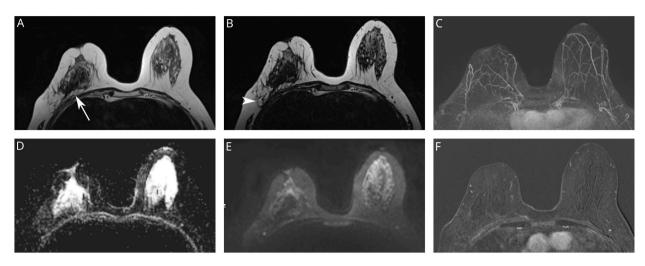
(A) T2-weighted sequences show asymmetric density and infiltration of the prepectoral fat pad (arrow). (B) T2-weighted sequences show marked architectural distortion due to a poorly defined hypo-intense mass (arrowhead) in the outer quadrant, which also causes nipple retraction. (C) On maximum intensity projection, asymmetry of breast size with a shrunken right breast is the main MRI sign of lobular carcinoma. No pathologic post-contrast enhancement is noted. (D) Diffusion-weighted image of *b-800* and (E) Apparent diffusion coefficient show that the mass is large and extends from the retro-areolar region to the pre-pectoral region, with infiltration along the areolar region and nipple. (F) Axial subtracted T1-weighted dynamic contrast-enhanced images show no contrast enhancement.
